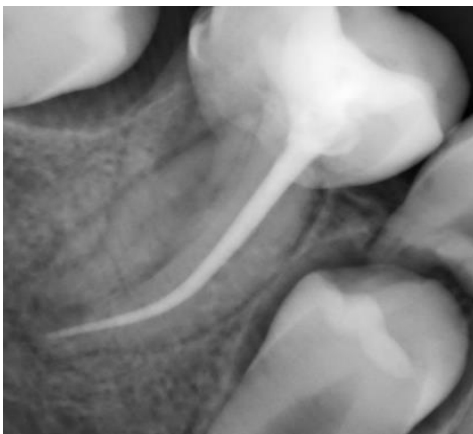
3rd month follow-up periapical image.
